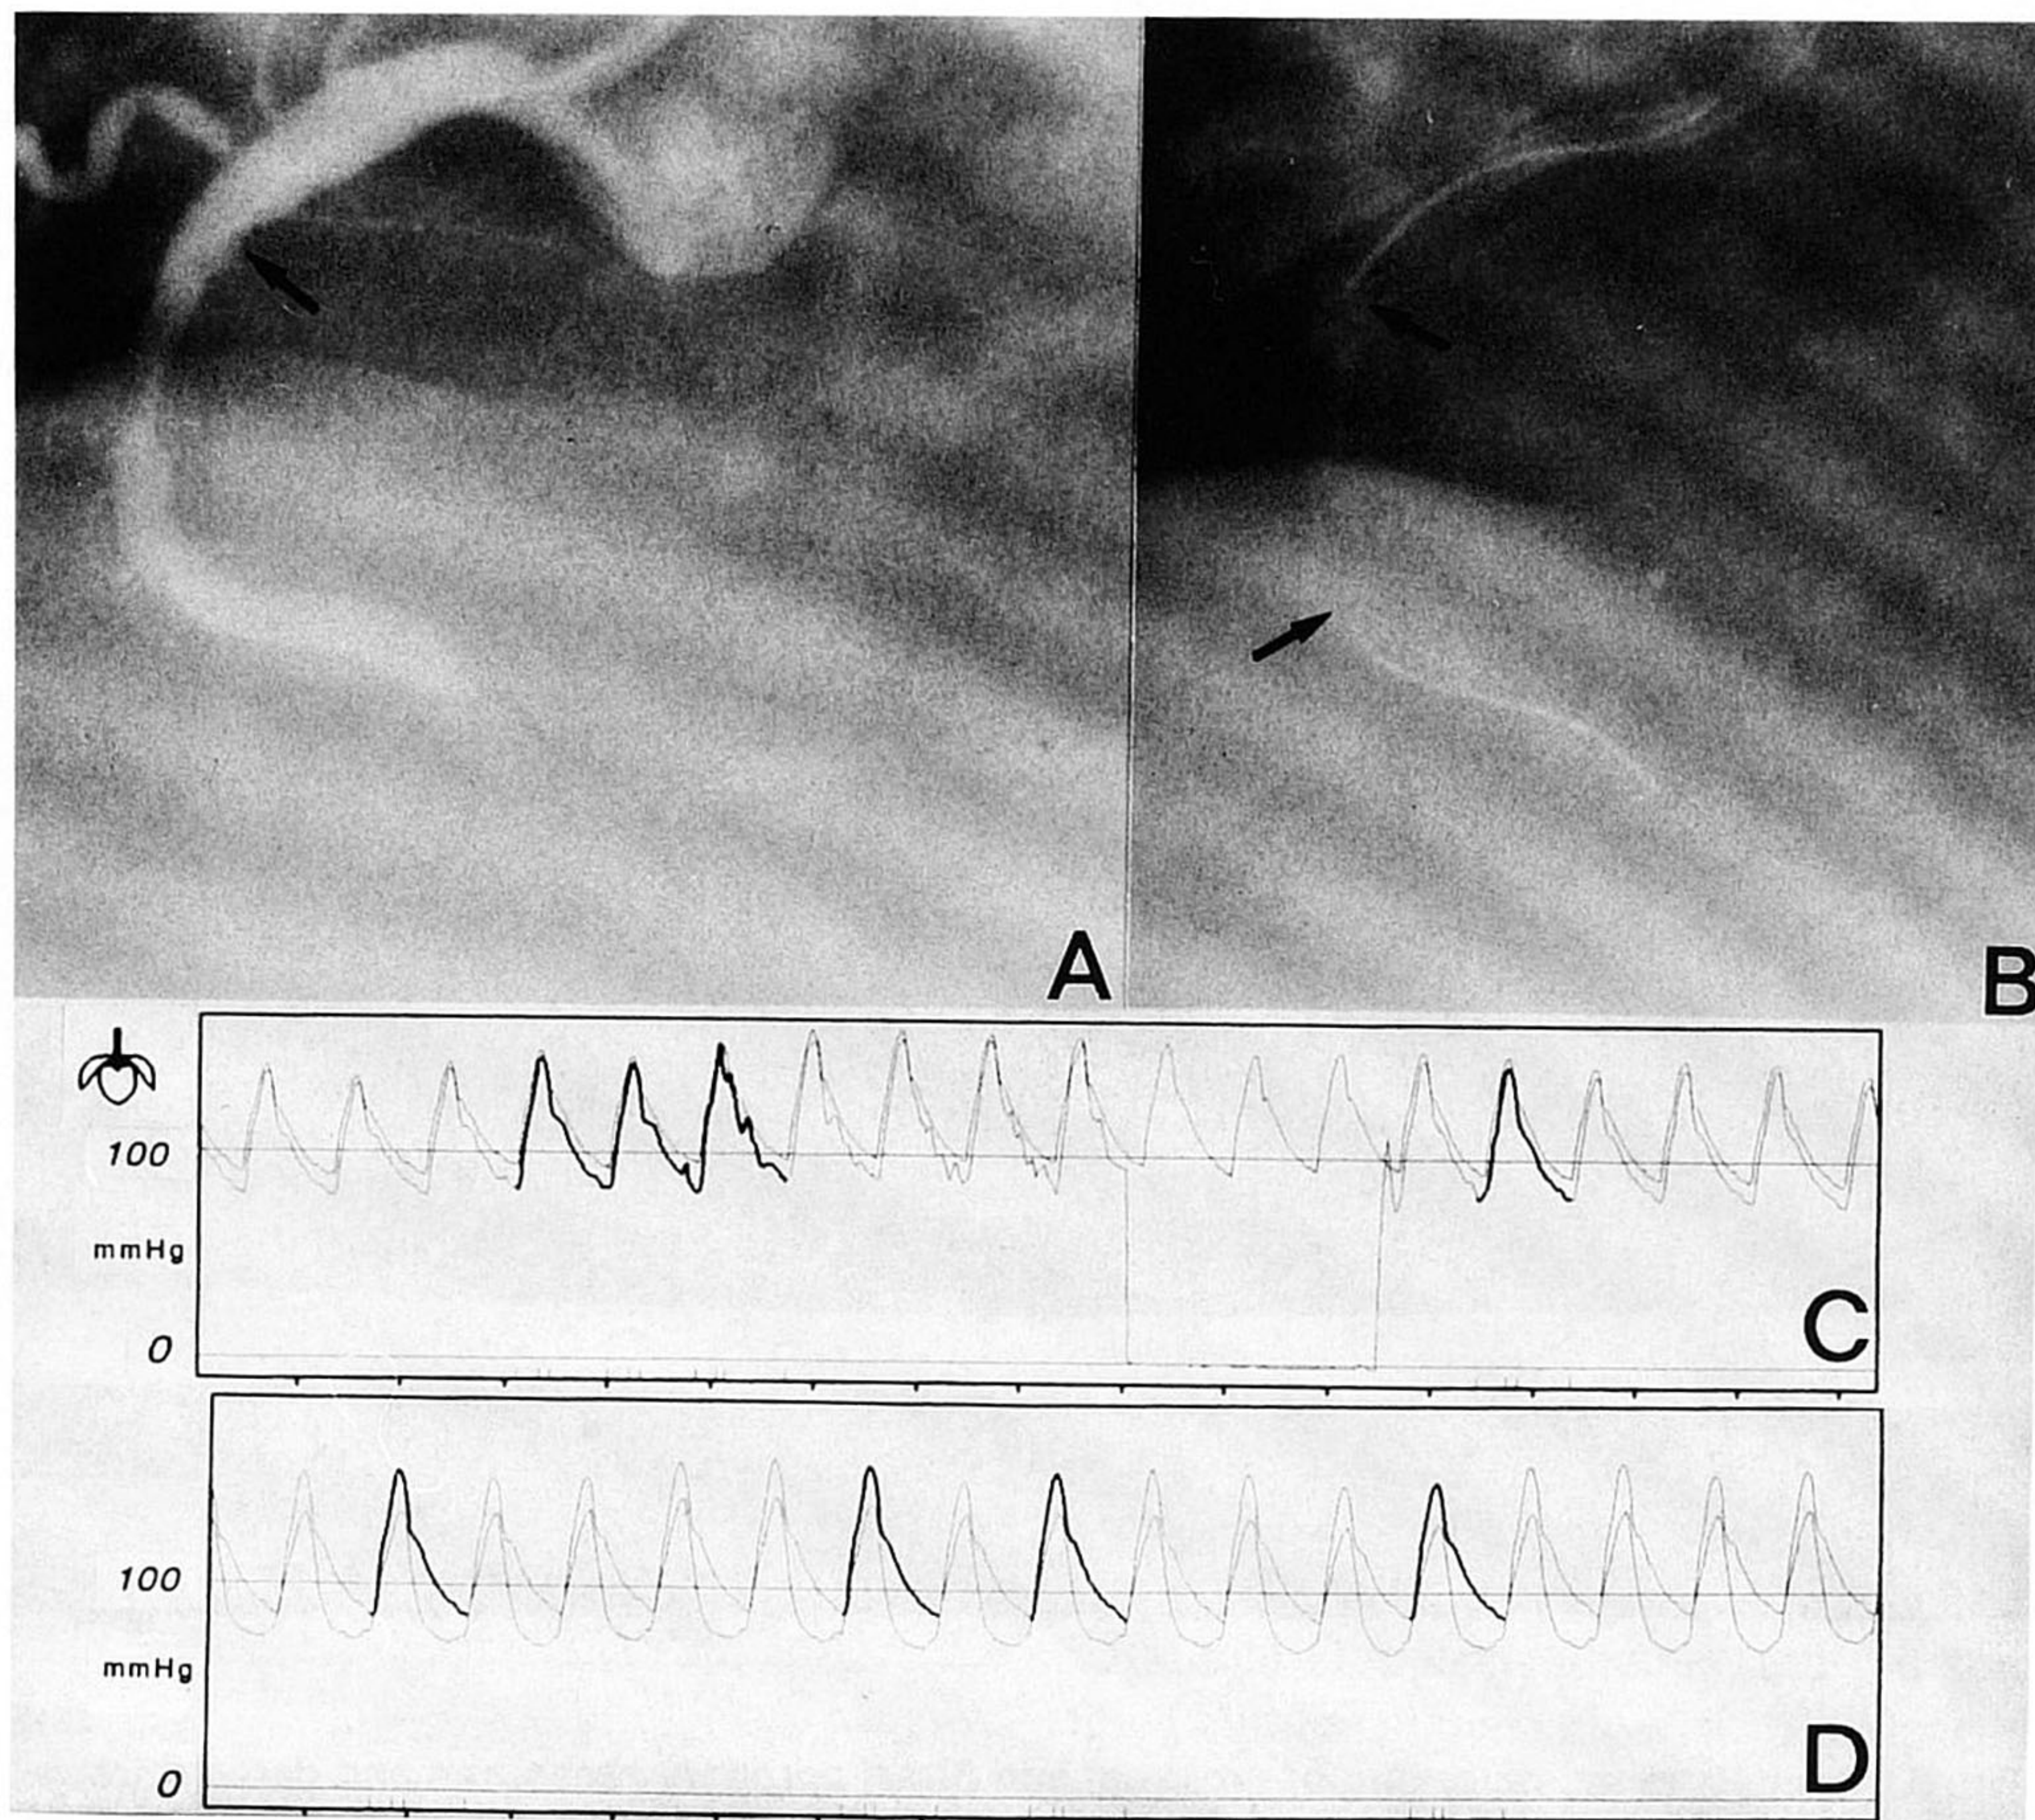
A: Cineangiogram of the right coronary artery showing the position of the Doppler guidewire, proximal to the stenosis (arrow). The position of the pressure sensor, at the junction between more radioopaque floppy distal tip and body of the guidewire, is better appreciated in the image without contrast (B, arrow). In C and D the almost complete superimposition of proximal and distal coronary pressures with the pressure transducer proximal to the stenosis (C) can be compared with the moderate pressure gradient observed in baseline conditions when the guidewire was advanced distal to the stenosis (D).
